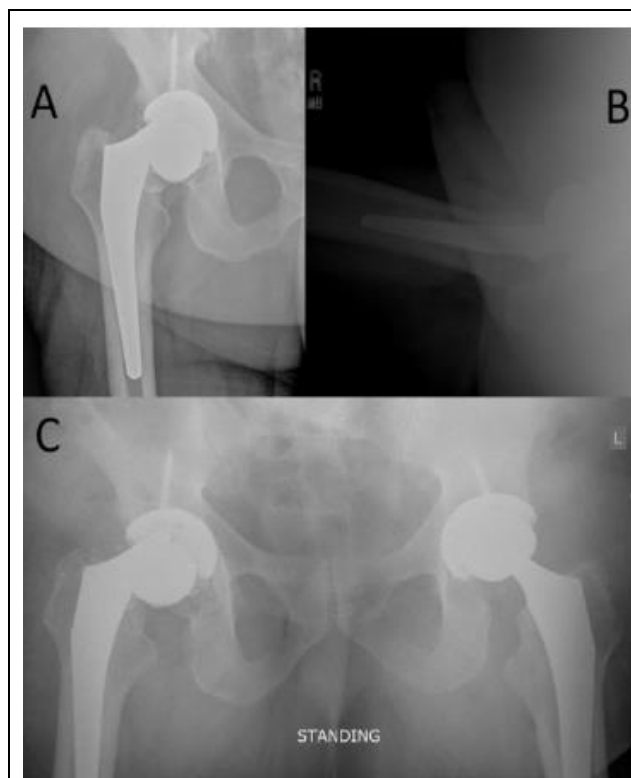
4A-4C Radiographs (Case 2). Preoperative anteroposterior right hip (A), lateral right hip (B), and anteroposterior pelvic (C) radiographs demonstrating gross trunnion failure with dissociation at the femoral head-neck junction.
